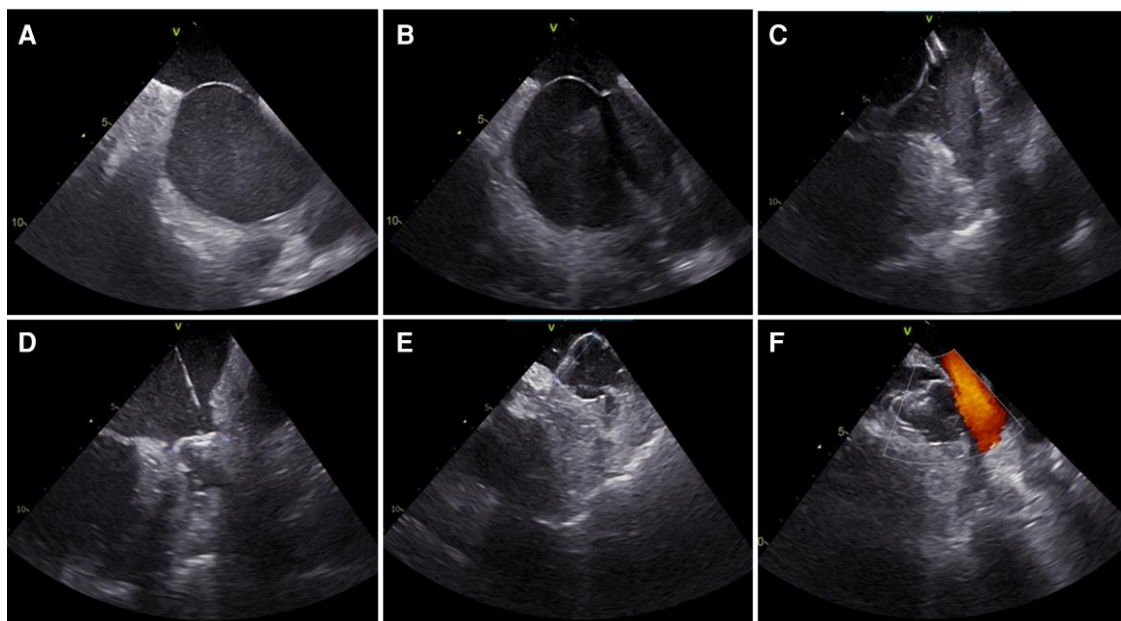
(A) Intracardiac echocardiogram catheter imaging of the atrial septum. (B) Intracardiac echocardiogram imaging showing Mullins catheter with NRG RF transeptal needle indenting the atrial septum prior to septal puncture. (C) Measuring the left atrial appendage orifice diameter with ICE catheter in the left atrium. (D) Measuring the compression of Watchman device from the mid-left atrium position. (E) Measuring the compression of Watchman device from the low-left atrium position. (F) Doppler imaging using intracardiac echocardiogram catheter in the left atrium.
